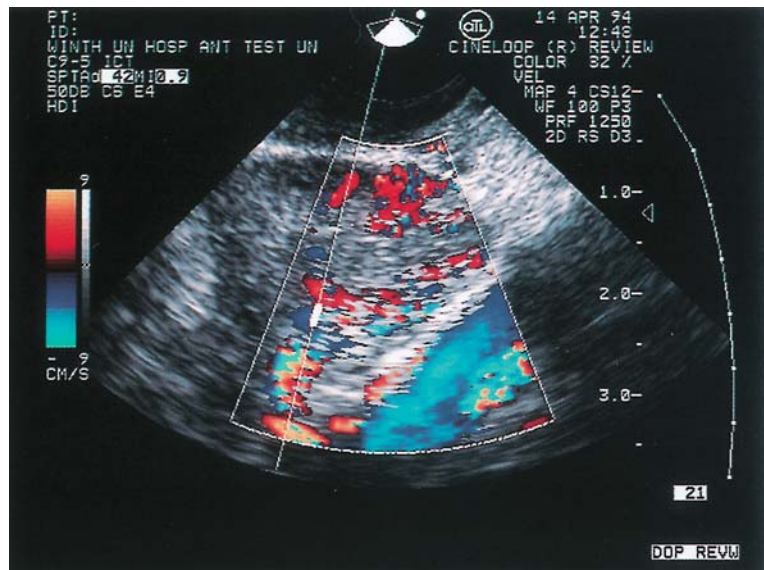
Small vessels around the mature follicle can also be visualized by color Doppler sonography
